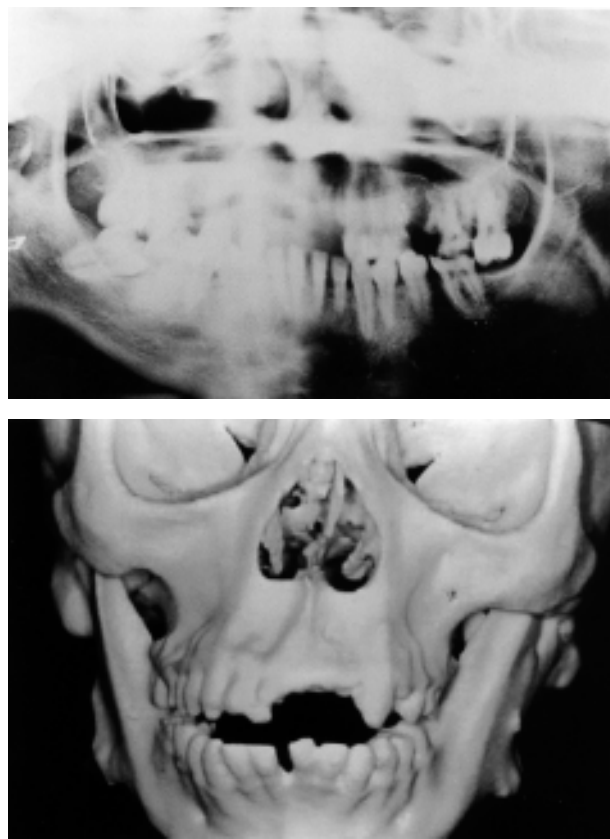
Panoramic x-ray and prototyped model.
